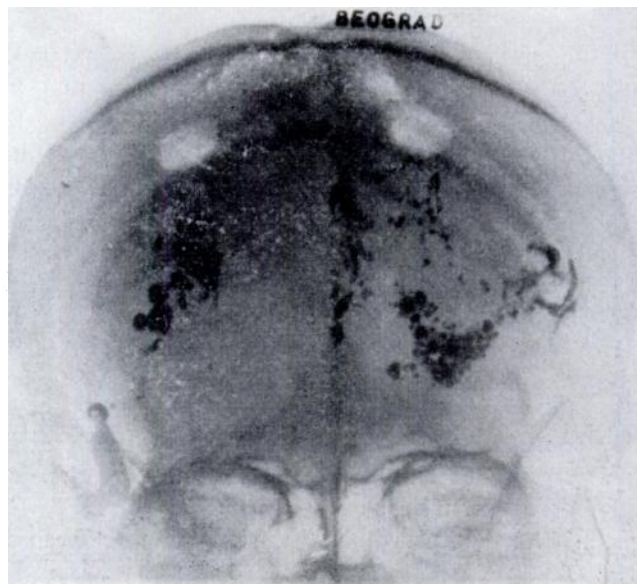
Myodil x-ray A-P picture of head immediately after leucotomy.
